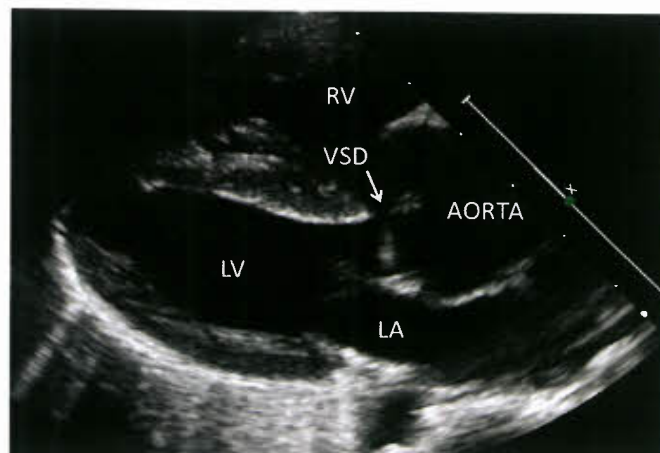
Typical parasternal long axis view in a patient with TOF. The aorta overrides the crest of the ventricular septum. VSD, ventricular septal defect; LV, left ventricle; RV, Right ventricle; LA, left atrium.
